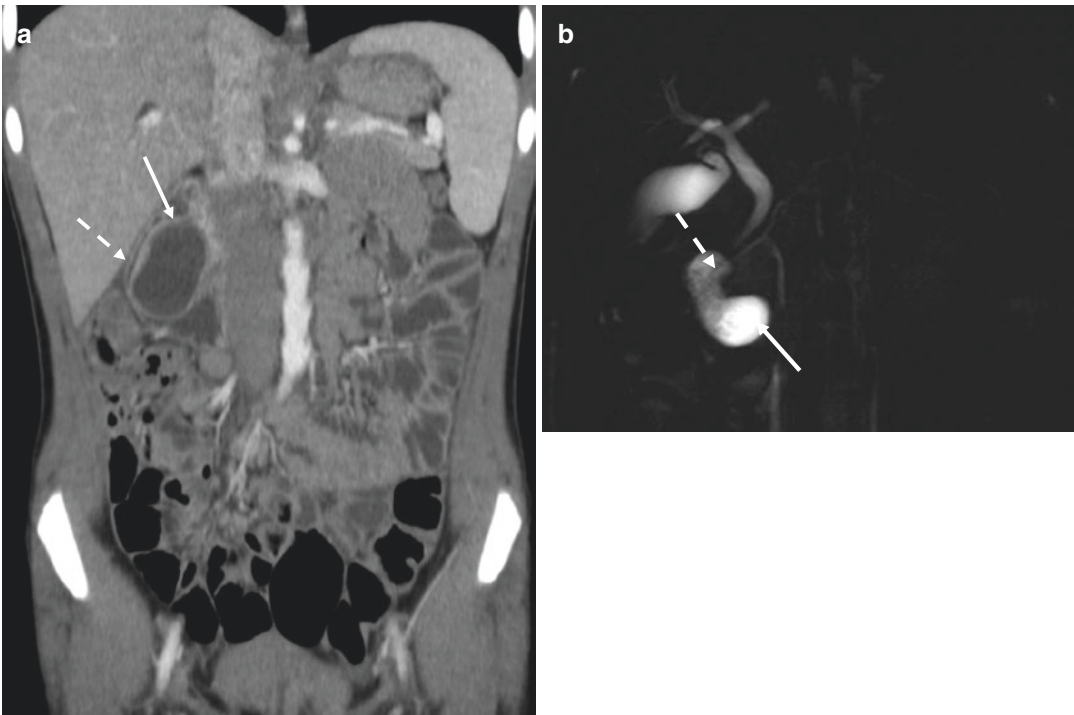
Duodenal duplication cyst in a 10-year-old girl with abdominal pain, fever, vomiting, and elevated pancreatic enzymes. (a) CE-CT coronal reformatted image shows an intraluminal cyst (*arrow*) in the second portion
